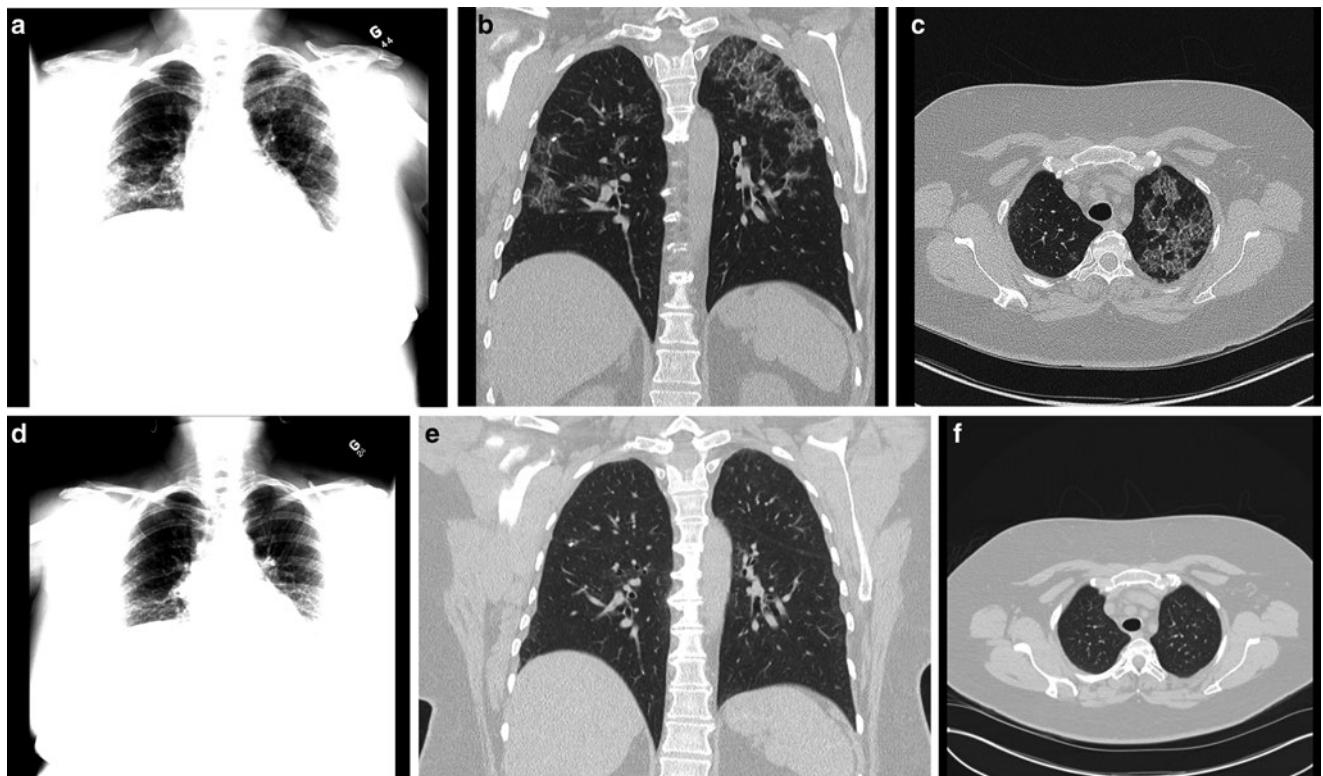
Radiological imaging of pulmonary alveolar proteinosis. (a) Antero-posterior view demonstrating the heterogeneous radiological infiltrations. They are mainly localized in the left superior lobe, and the supero-dorsal segment of the bilateral inferior lobes. (b) High definition computed tomography scan, coronal plane, showing the same involvement. (c) High definition computed tomography scan, axial plane, showing crazy paving imaging in the left upper lobe. (d) Antero-posterior view demonstrating the disappearance of the radiological infiltrations. (e) High definition computed tomography scan, coronal plane, showing the same improvement. (f) High definition computed tomography scan, axial plane, showing that the alveolar material has cleared out.
